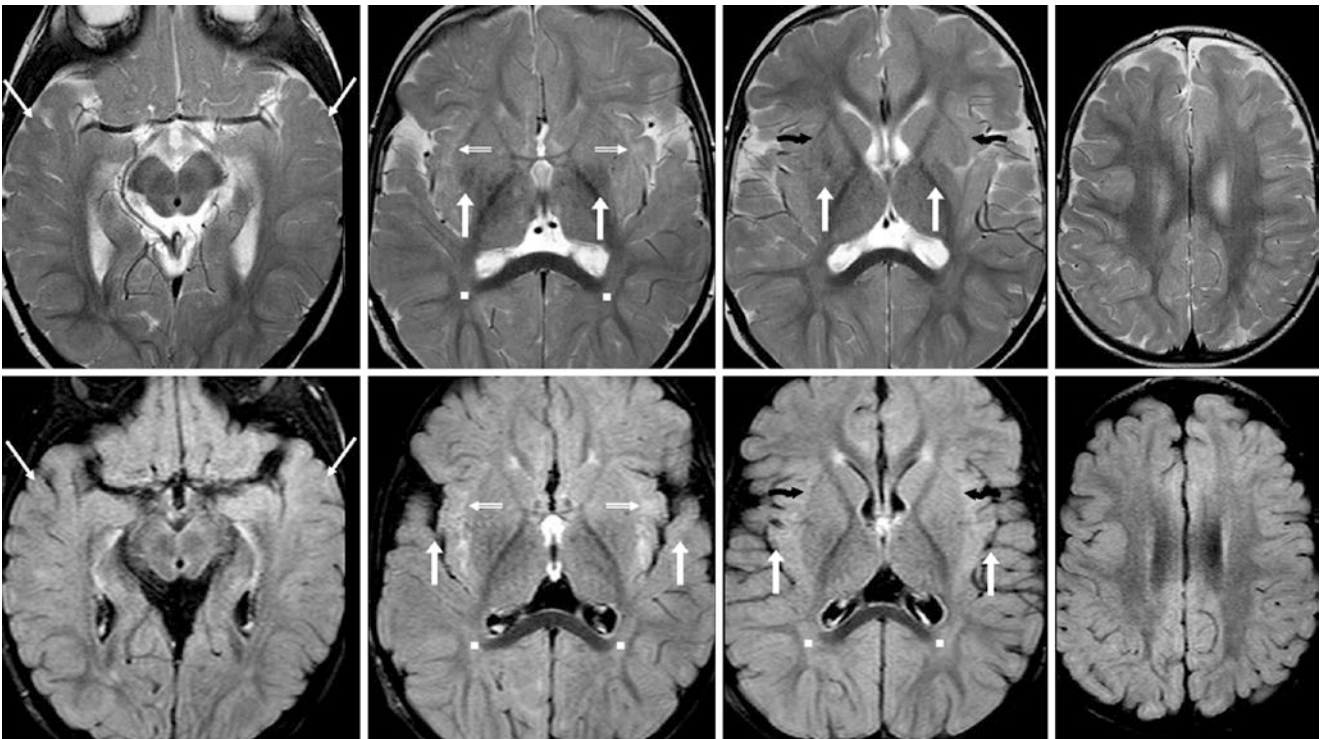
A developmentally normal 15.5-month-old with “spells” had a normal 3T MRI. The anterior commissure and EC (crooked arrows) are myelinated on axial SE T2WIs (top row) and FLAIR images (bottom row). There is mild hyperintensity of the SIWM
